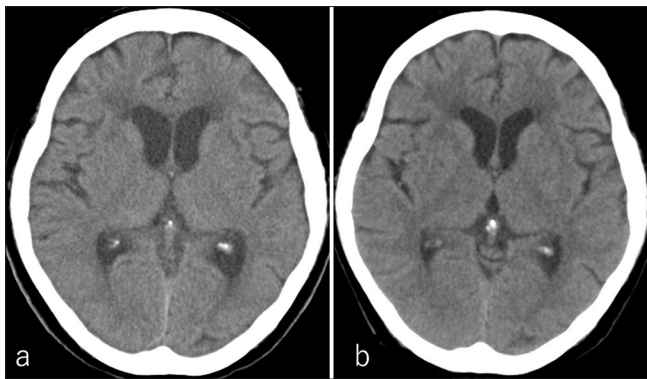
(a and b) Computed tomography performed on (a) postoperative day (POD) 48 and (b) POD 59 showing resolution of ventricular dilation after placement of lumboperitoneal shunt.
